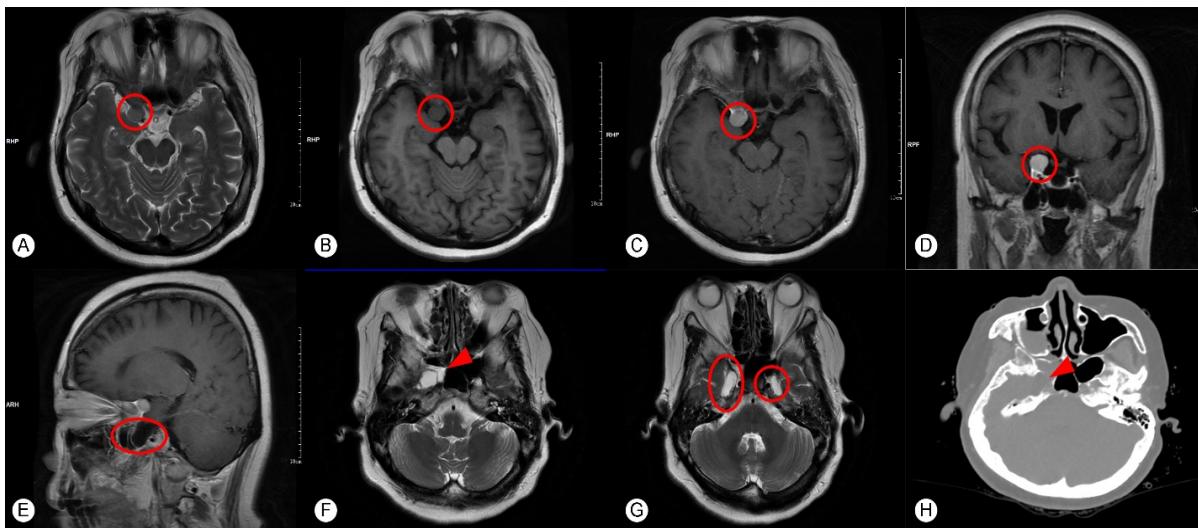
The preoperative imaging data of Case 1. (A) and (B). MRI scan indicates an occupancy with equal signal in T1 and equal-high signal in T2 in the right anterior clinoid process. (C) and (D): Enhanced MRI scan indicates the mass was uniformly enhanced, suggesting an anterior clinoid meningioma. (E)~(G): MRI T2 weighted imaging shows abnormally high signal intensity, and the red arrow indicates the ruptured area formed by meningeal protrusion, which is the site of cerebrospinal fluid nasal leakage. (H) The 3D thin-layer brain CT bone window shows a bone defect in the lateral wall of the sphenoid sinus. Cerebrospinal fluid images can be seen in the sphenoid sinus, posterior ethmoid sinus, and maxillary sinus, and there is excessive gasification of the bilateral sphenoid sinus lateral crypts
